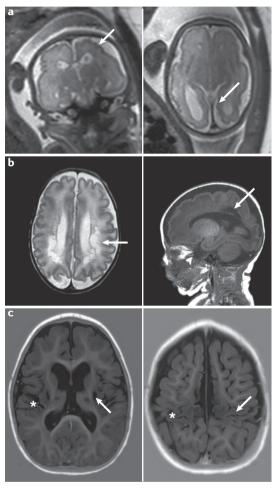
Brain lesions in cerebral palsy. a | Coronal (left) and axial (right) MRI scans at 32 weeks of gestation showing frontal lobe hypoplasia and polymicrogyria (arrow). The child developed severe bilateral spastic cerebral palsy (Gross Motor Function Classification System (GMFCS) level V). b | Axial (left) and sagittal (right) MRI (spin echo T2 and spin echo T1) scans obtained at 5 weeks in an infant born preterm (at 30 weeks of gestation). Images show cystic periventricular leukomalacia (arrow). The child developed severe bilateral spastic cerebral palsy (GMFCS level IV). c | Axial MRI (inversion recovery) images obtained at 3 years in a child with birth asphyxia at term, showing cortico-subcortical atrophy particularly marked in the perirolandic region (asterisk) and porencephalic cysts in the basal ganglia bilaterally (arrow). The child had severe mixed-type (spastic and dyskinetic) cerebral palsy (GMFCS level V). Images are courtesy of C. Christophe, Université Libre de Bruxelles, Brussels, Belgium, and M. Cassart, Ixelles Hospital, Brussels, Belgium.
